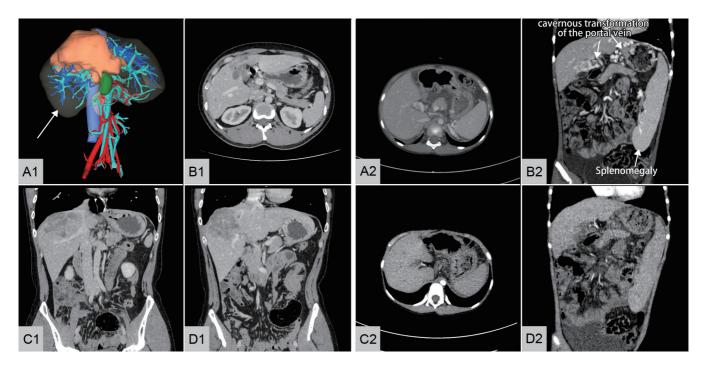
The enhanced CT scan and 3D model of the two patients. (A1-D1) The enhanced CT scan of the hepatic AE patient (A1: the 3D model of the CT images; B1: coronal position/venous phase; C1: sagittal position/venous phase; D1: sagittal position/arterial phase). (A2–D2) The enhanced CT scan of the girl with PV cavernous transformation and portal hypertension (A2: coronal position/venous phase; B2: sagittal position/venous phase; C2: coronal position/arterial phase). CT, computed tomography; AE, alveolar echinococcosis; 3D, three-dimensional; PV, portal vein.
